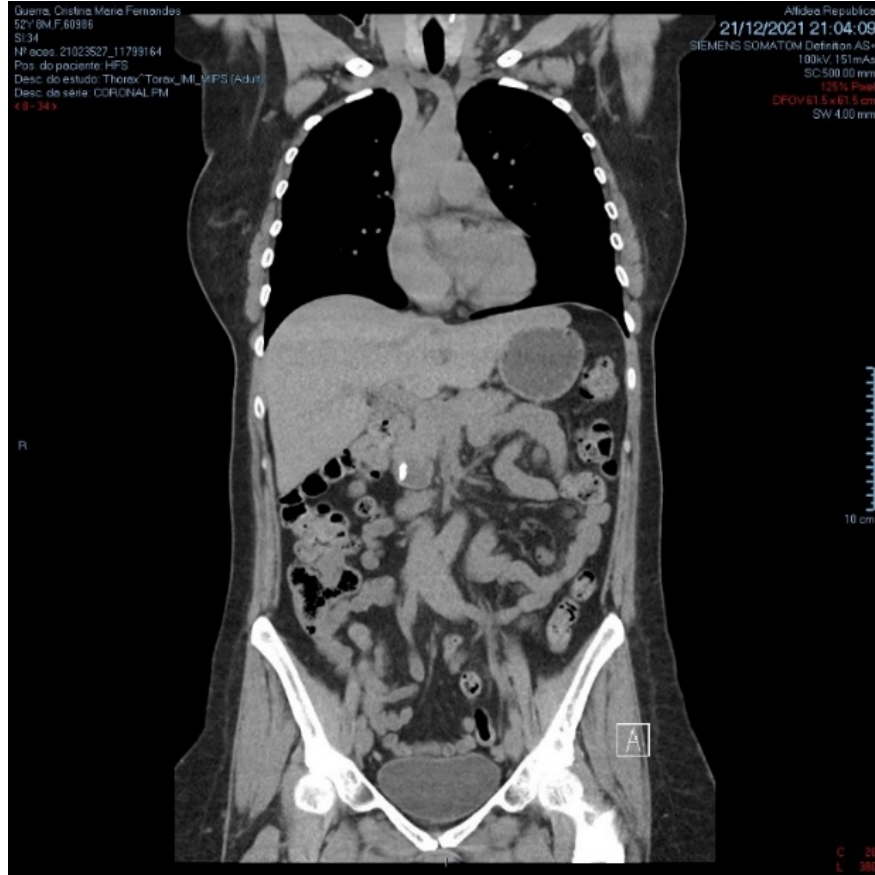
Abdominal CT showing a heterogeneous 3cm mass of uncinus pancreatic process with calcifications; the pancreatic duct was not dilated.
